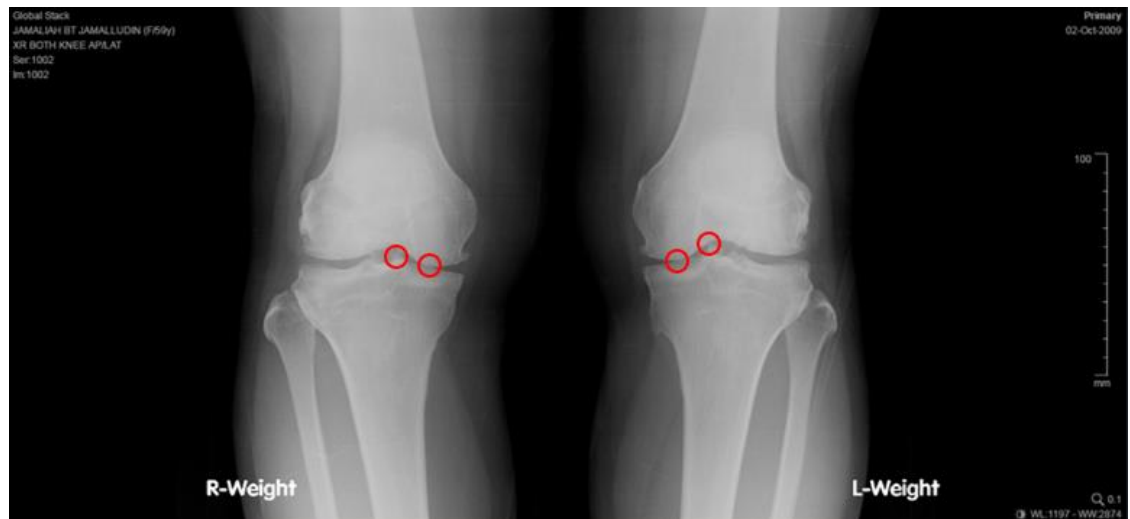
X-ray photo capture of grade 3 knee OA patient
